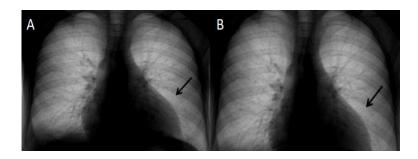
Chest X-rays showing pleural (A) and pericardial (B) effusions.
